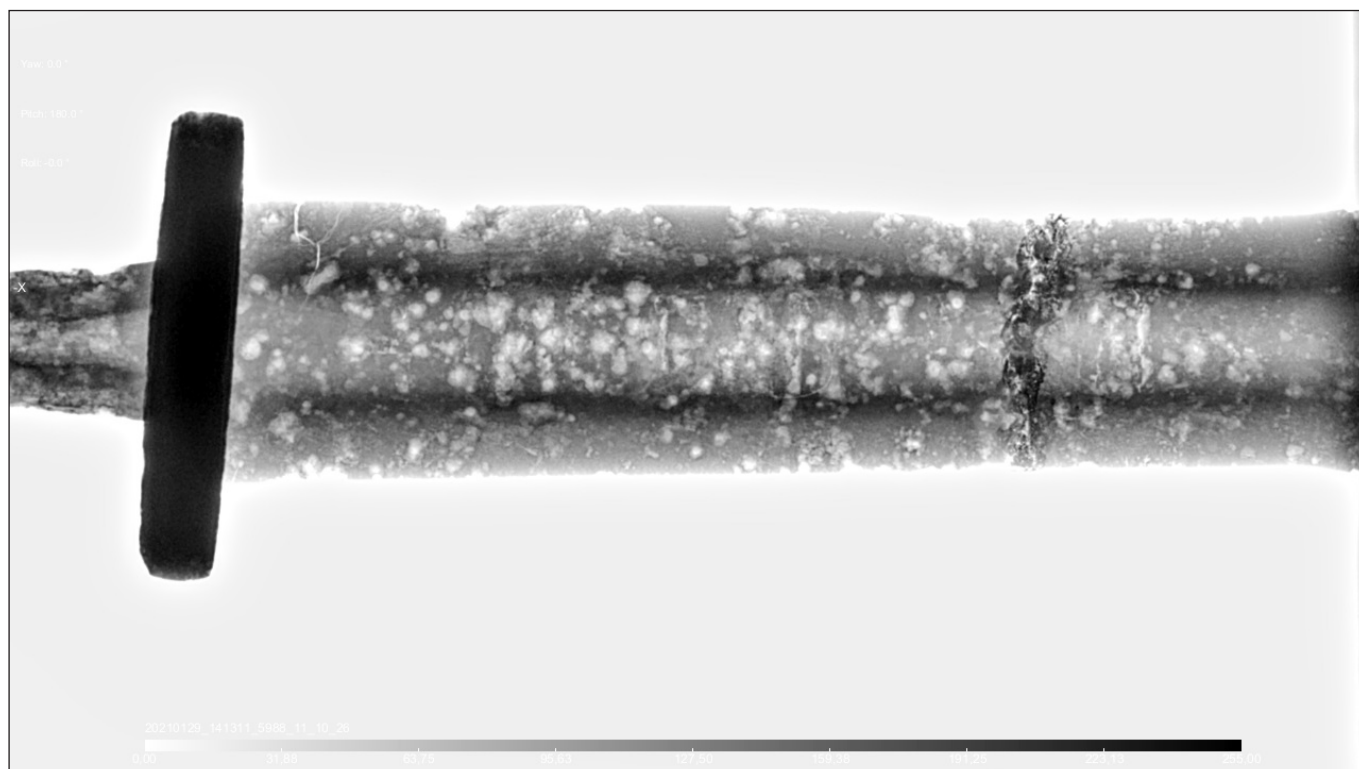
X-ray scan of one of the swords from Székesfehérvár-Rádiótelep, transformed into a different colour scale with the Dragonfly image analysis software.
